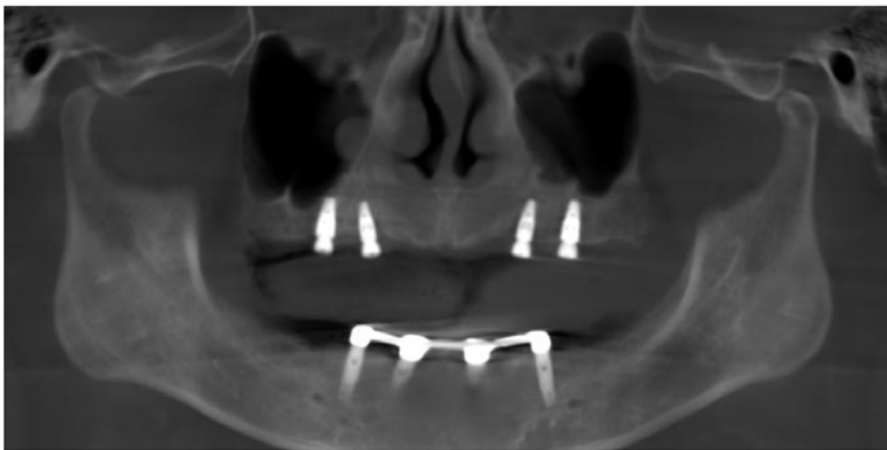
Panoramic view of CBCT image after #15 implant re-installation.
